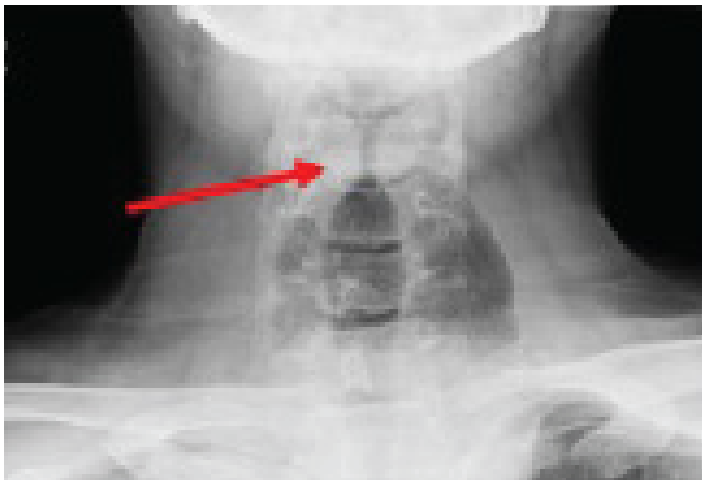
Anterior/posterior soft-tissue neck radiograph demonstrating proximal narrowing (arrow). Air seen in tissue surrounding trachea, originally thought to be pneumomediastinum, clinically correlates to esophagus.
